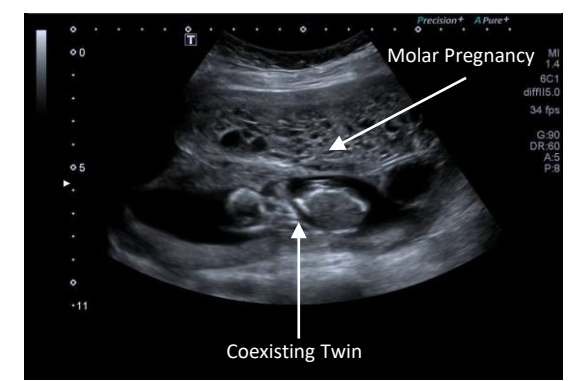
Ultrasound at 14 weeks: Placenta with multiple cystic spaces consistent with molar pregnancy
